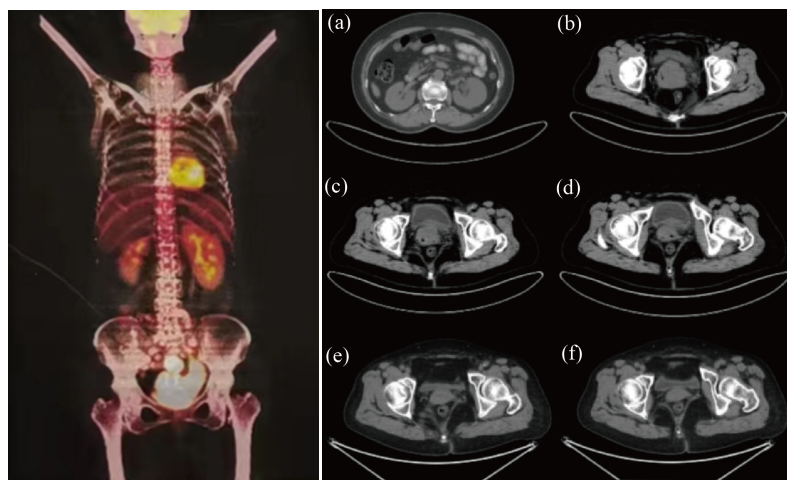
PET/CT images of the patient
